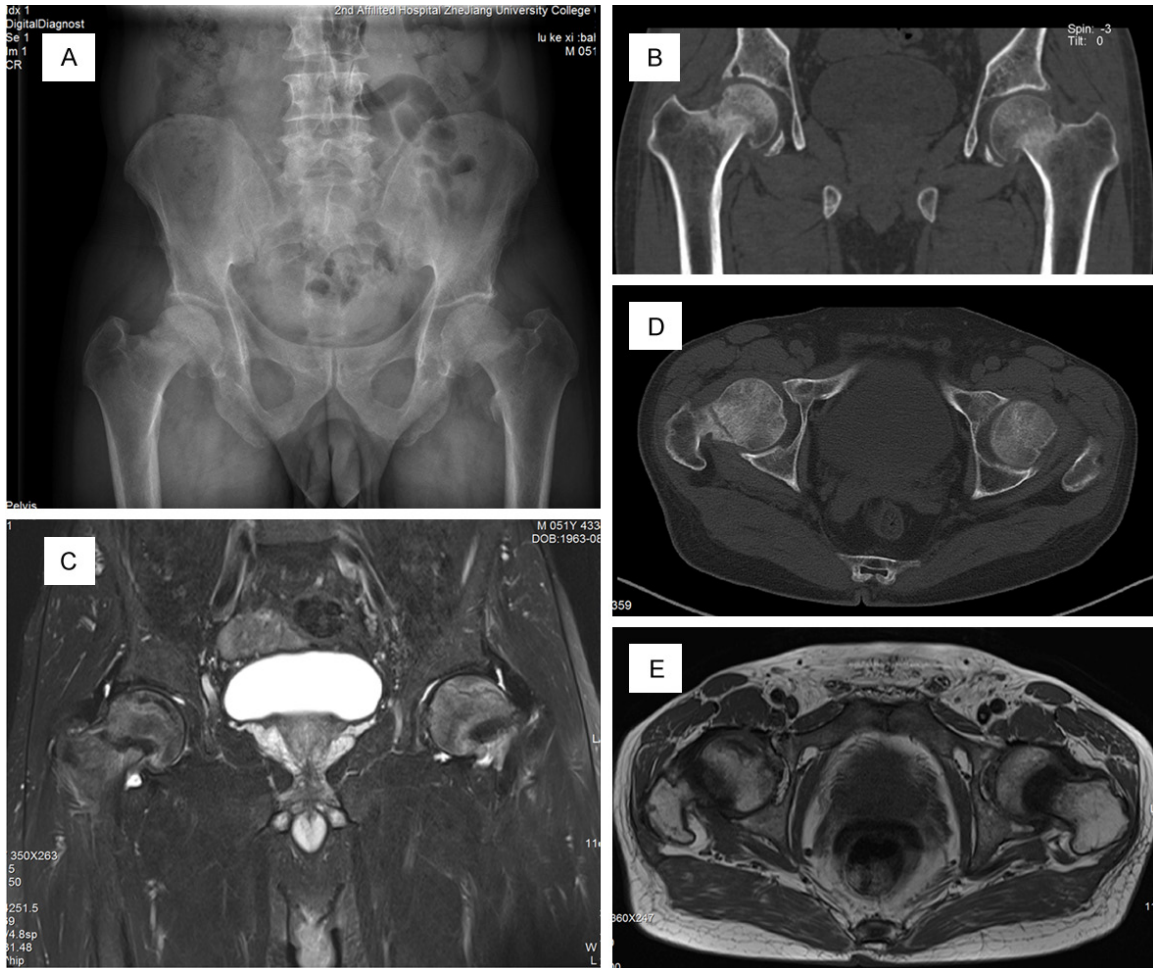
Radiological examinations at admission. A: Plain radiograph of the pelvis and both femoral heads showed bilateral femoral neck fractures. B, C: Computer tomography (CT) scan also showed bilateral femoral neck fractures. D, E: Magnetic resonance imaging revealed bilateral femoral head necrosis and neck fractures.
